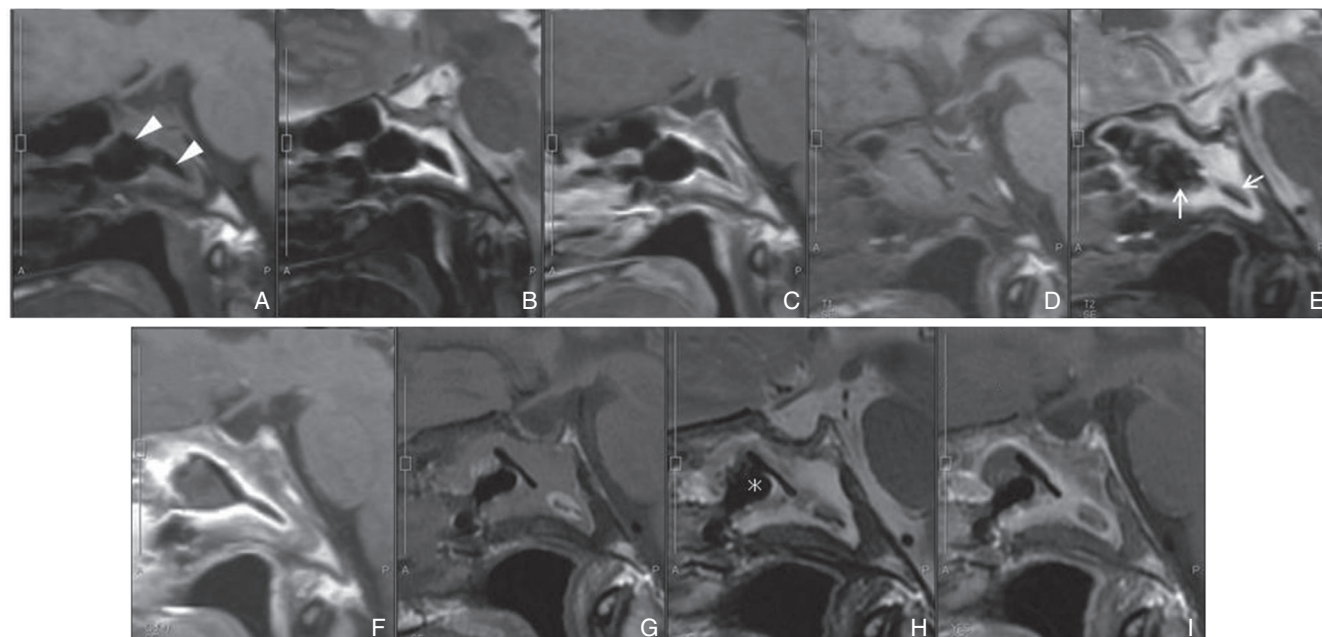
MRI 3 years after second TSS [A: T₁-weighted image (WI), B: T₂-WI, and C: gadolinium enhancement image] revealed the dropped-out bone grafts (arrowheads) were exposed to air. MRI 5 years after TSS (D: T₁-WI, E: T₂-WI and F: gadolinium enhancement image) showed a hypointense area (arrows) appeared at the area exposed to air and gadolinium bright enhancement was present around the bone grafts, suggesting that an airborne fungal infection had developed. MRI 8 years after the TSS (G: T₁-WI, H: T₂-WI, and I: gadolinium enhancement image) indicated presence of sphenoiditis. The area surrounding the bone grafts were observed as hyperintensity on the T₁-WI and hypointense on the T₂-WI with gadolinium enhancement around the mass, suggesting fungal lump. A biopsy was performed (asterisk) to detect *Aspergillus*. MRI: magnetic resonance imaging, TSS: transsphenoidal surgery.
